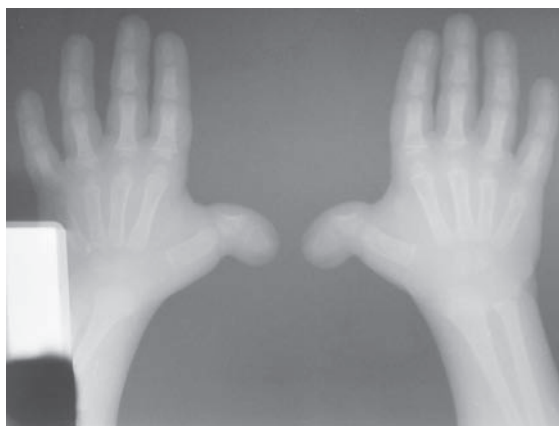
Hand X-ray showed broad and short terminal phalanges and triangular proximal phalanges of thumb.
